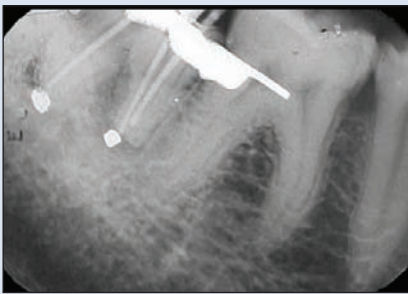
Intraoral periapical (IOPA) radiograph taken at the patient's first visit in 2004. Root resorption is distinct but the periodontal ligament space seems to be intact, with slight radiolucency around the mesial root. There is no evidence of ankylosis.
